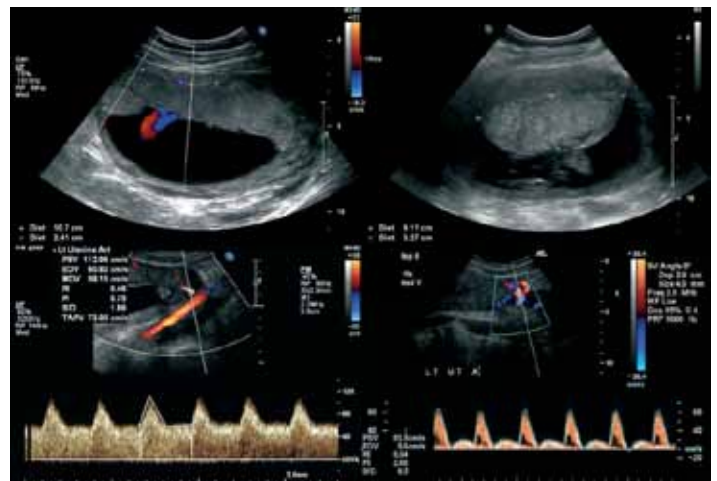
Ultrasonographic evaluation of UtA doppler and placental size. On the left a thin and long placenta and UtA Doppler waveform where PI $<1,45$ which is considered to be normal; on the right a thick and small placenta and UtA Doppler waveform had elevated PI which is considered to be abnormal.
